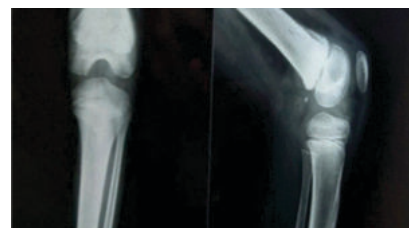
Radiograph at 1 month follow-up and k wire removed
